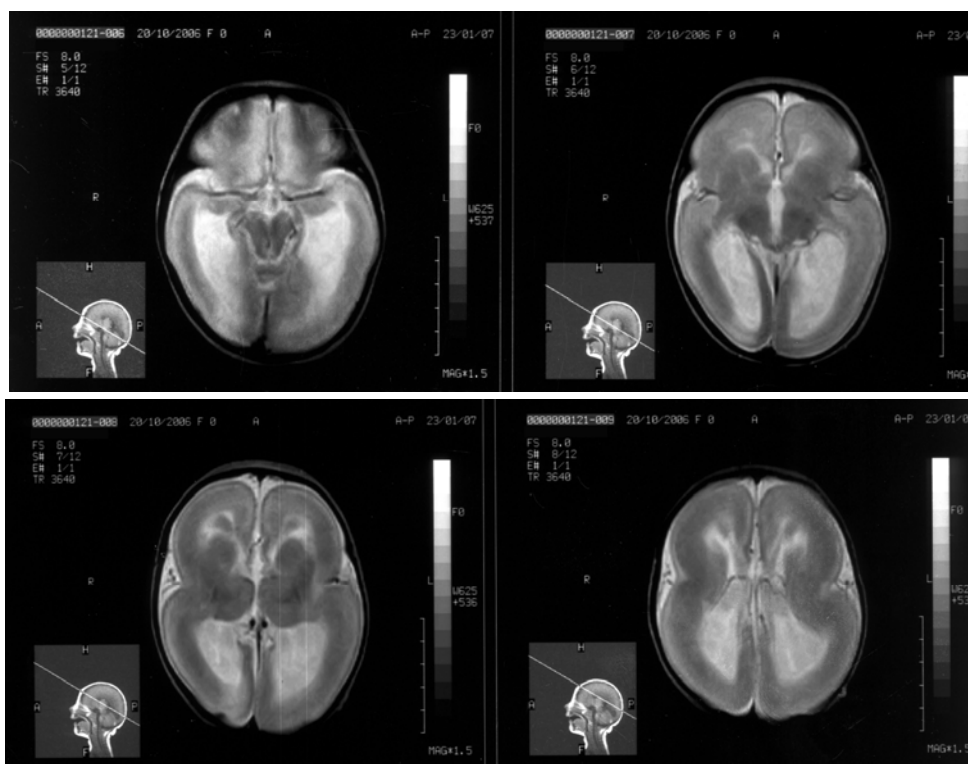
Axial magnetic resonance images at the age of two months shows colpocephaly, the absence of gyration and an open insula - features typical for lissencephaly.
